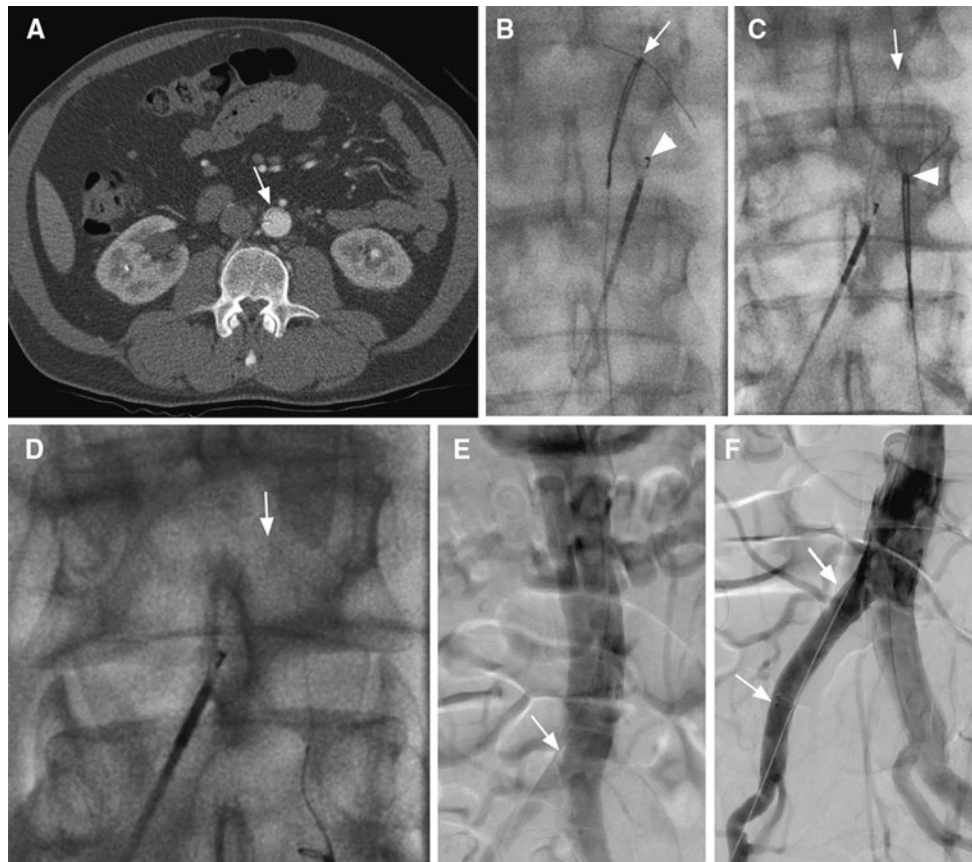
Sixty year old male patient with acute thoraco-abdominal type B dissection, clinically presented with acute ischemia of the right leg. CTA (A) demonstrates a severely compressed true lumen within the infrarenal abdominal aorta (arrow). The dissection membrane was then perforated (B) using a combination of outback catheter (arrowhead) and 0.014-inch wire, the latter being snared through a contralateral transfemoral approach (arrow). Using the snared wire
